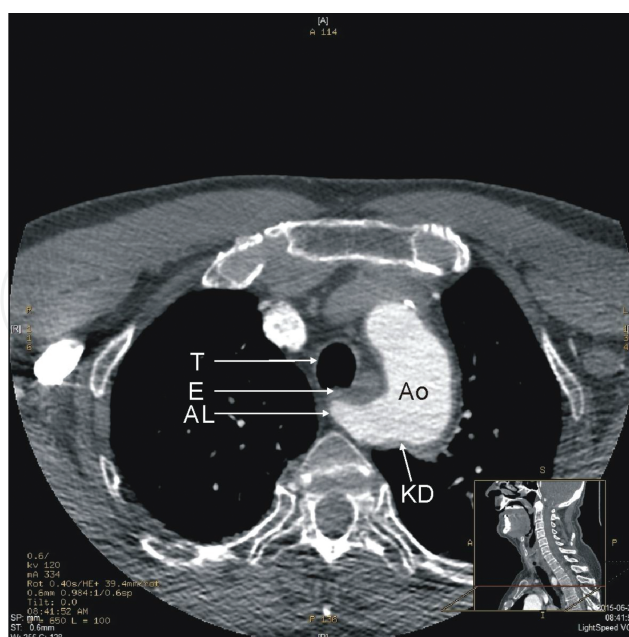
Computed tomography transverse scan on the level of the arch of the aorta. Ao—arch of the aorta, AL—arteria lusoria, E—esophagus, KD—Kommerell's diverticulum, T—trachea.
